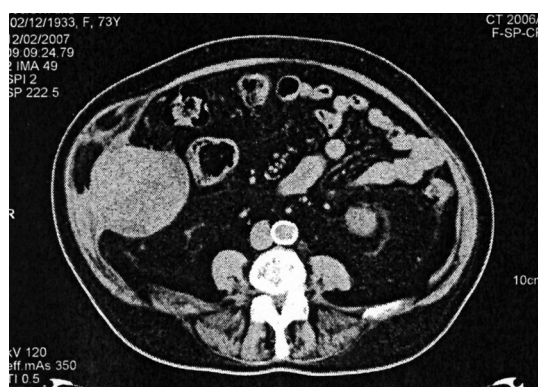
CT scan of the lower abdomen showing the abdominal wall mass with thickened and bulging abdominal wall and no communication with the cecum.
